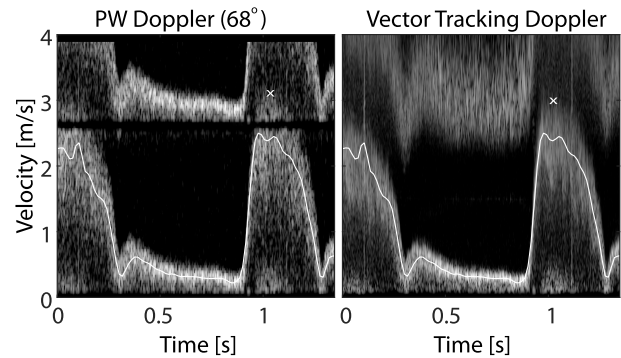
Vector PW and vector tracking Doppler spectra from the stenotic region indicated by a white square in Fig. 13. Maximum velocities are close to 3 m/s. Note that there is a band of missing signal around $2 v_{Nyq}$ in the PW Doppler case, which is not present when using vector tracking Doppler. White line: estimated vector velocity magnitudes. White markers: envelope for the maximum velocities.
